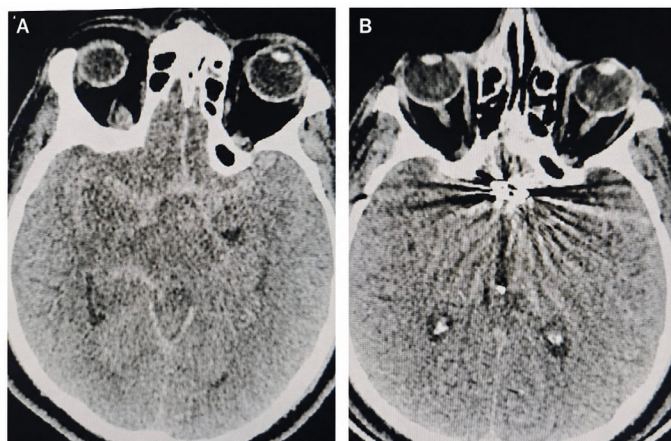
Representative cranial CT images of a patient with a ruptured anterior communicating artery aneurysm and a favorable functional outcome; (A) Preoperative cranial CT showing subarachnoid hemorrhage; (B) Postoperative cranial CT demonstrating the aneurysm clip
